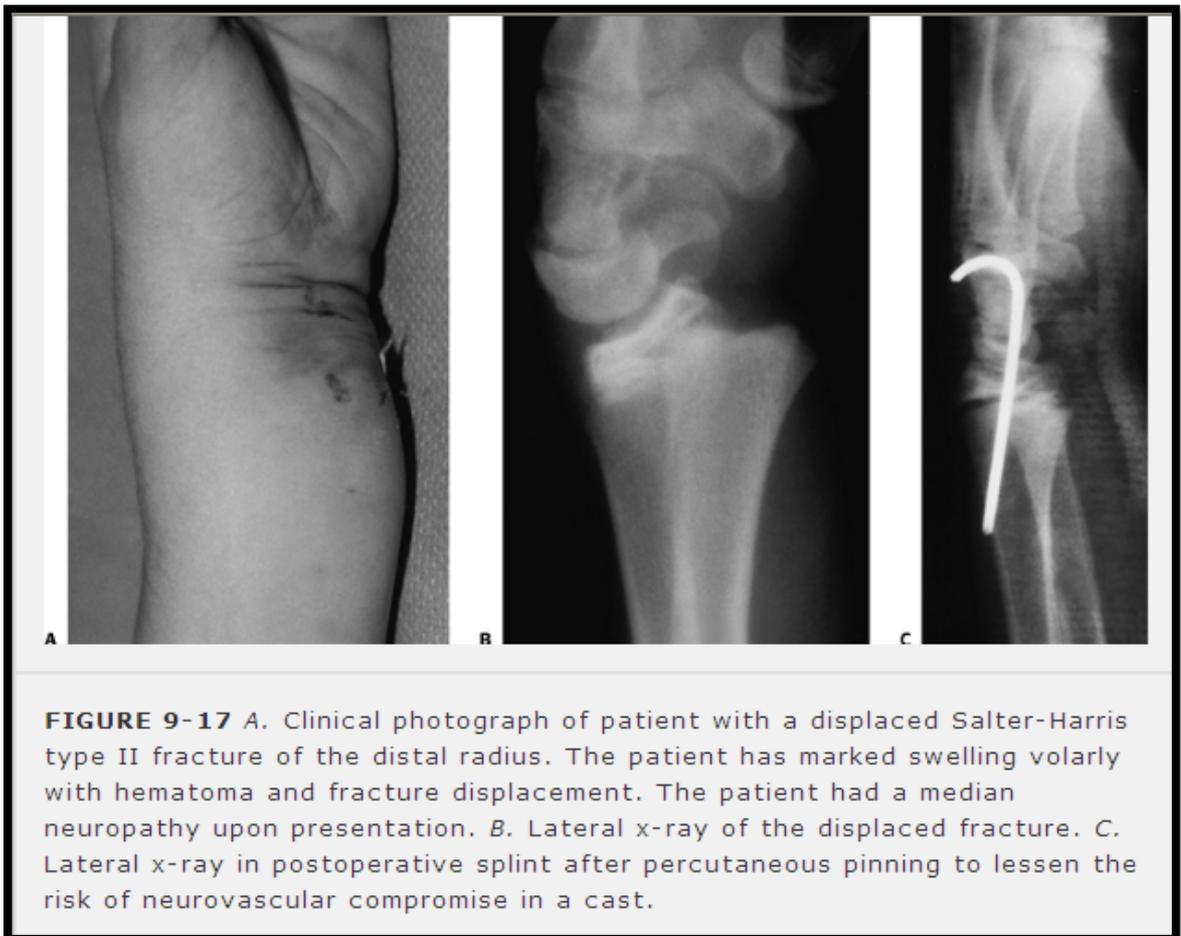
A. Clinical photograph of patient with a displaced Salter-Harris type II fracture of the distal radius. The patient has marked swelling volarly with hematoma and fracture displacement. The patient had a median neuropathy upon presentation. B. Lateral x-ray of the displaced fracture. C. Lateral x-ray in postoperative splint after percutaneous pinning to lessen the risk of neurovascular compromise in a cast.
